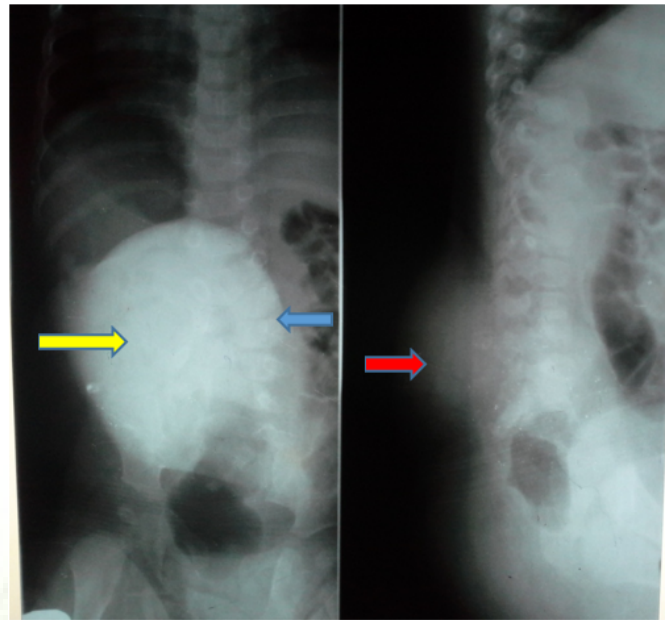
Plain radiograph of the lumbosacral spine anterior-posterior (AP) on the left and lateral view on the right showing scoliosis of the lumbosacral spine (left blue arrow) and a soft tissue density mass in the distal spine; posteriorly located on the lateral view (right red arrow) and right lateral aspect of the spine on the AP view (right yellow arrow).
